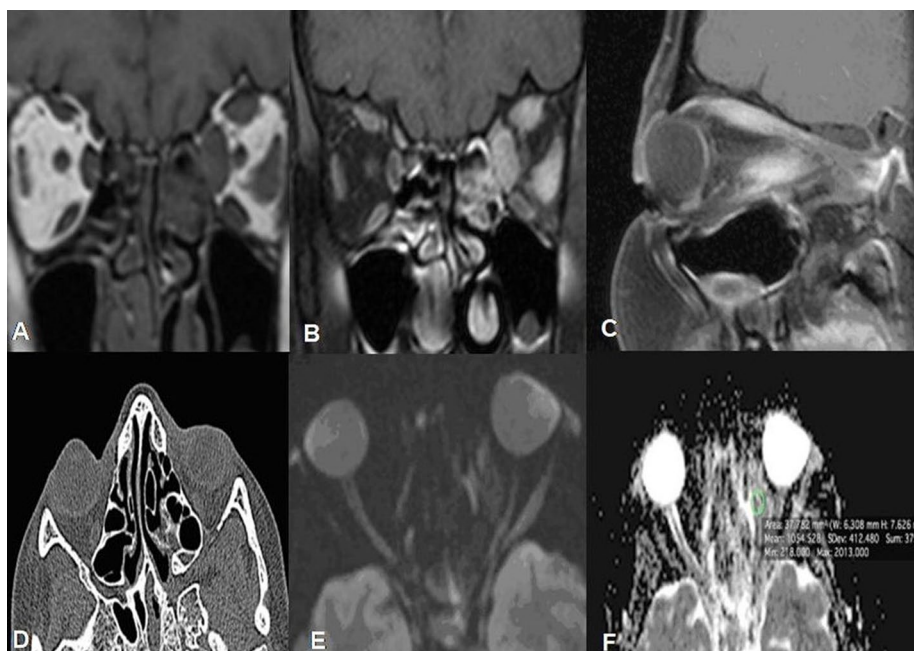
A 23-year-old male patient with acute rhino-sinusitis presented with left-sided orbital pain, mild proptosis and limited orbital gaze. Coronal T1 A shows diffusely enlarged left superior, medial and lateral recti with mild stranding of the left retrobulbar fat. Coronal and sagittal T1 fat-sat post-contrast images B, C show homogeneous enhancement of these left orbital muscles. Axial non-contrast CT image bone window D reveals ethmoidal and sphenoidal mild sinusitis. No diffusion-weighted restriction seen on DWI (b_{500}) E and ADC F. The ADC value is $1.05 \times 10^{-3} \text{ mm}^2/\text{sec}$. Left-sided orbital inflammatory pseudotumor, Myositic type; responded well 2 weeks after therapeutic trial with corticosteroids
